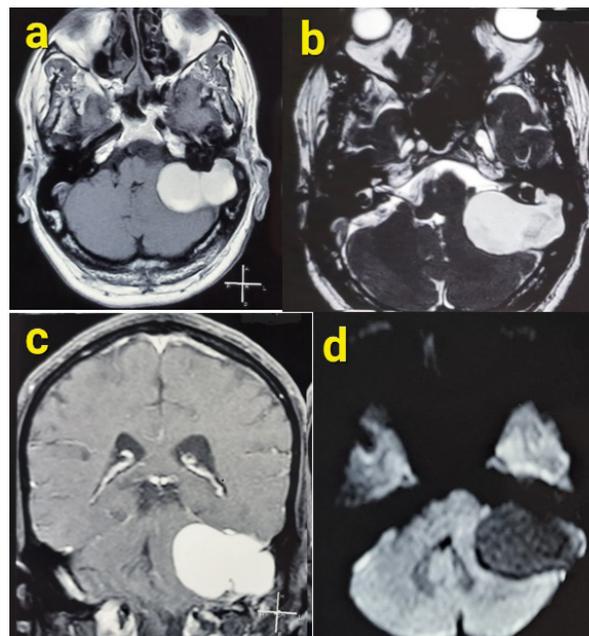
MRI scan of petrous neurenteric cyst
